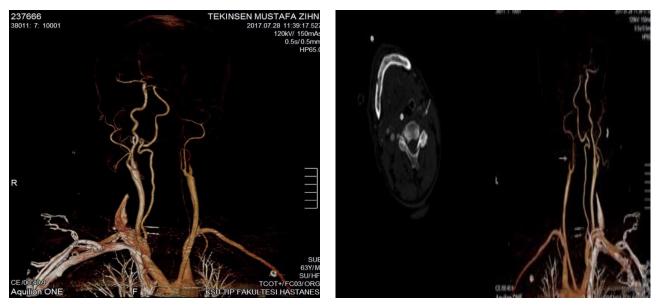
Dissection of the left internal carotid artery in neck CT angiography
